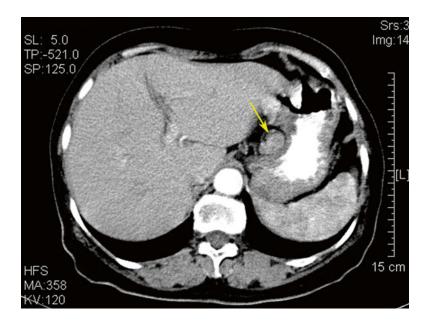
CT scan showing No. 3 LNM (the *arrow* represents the swollen No. 3 LNs)
